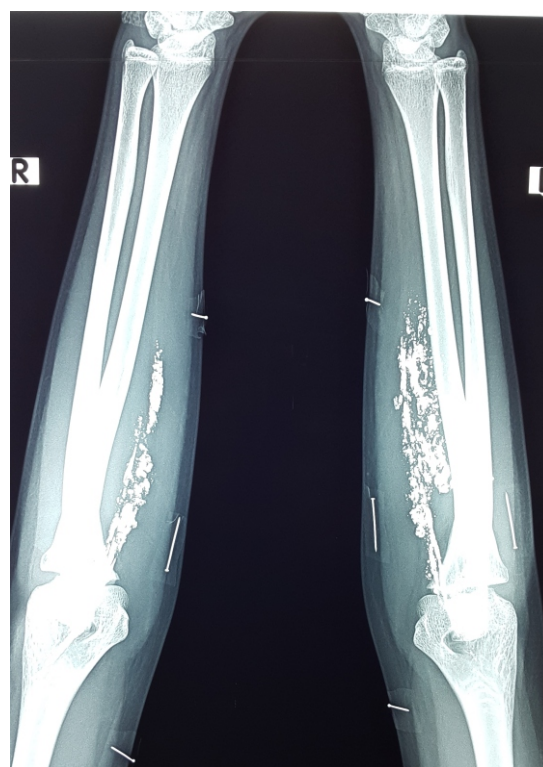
X-ray showing multiple opaque shadows of mercury and pre-op markers.
